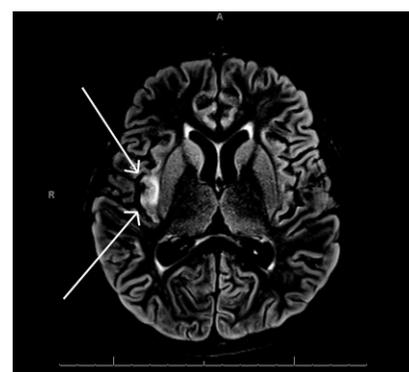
Axial T2 MRI brain revealing hyperintensity in the right insular cortex.
